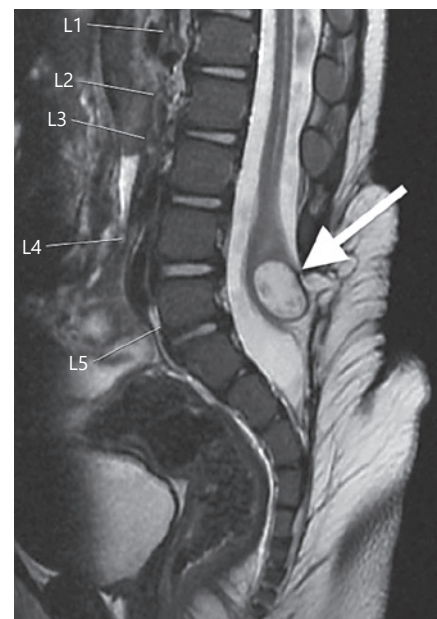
MRI demonstrating a spinal inclusion cyst (arrow) in a 13-month-old child after fetal spina bifida repair.
